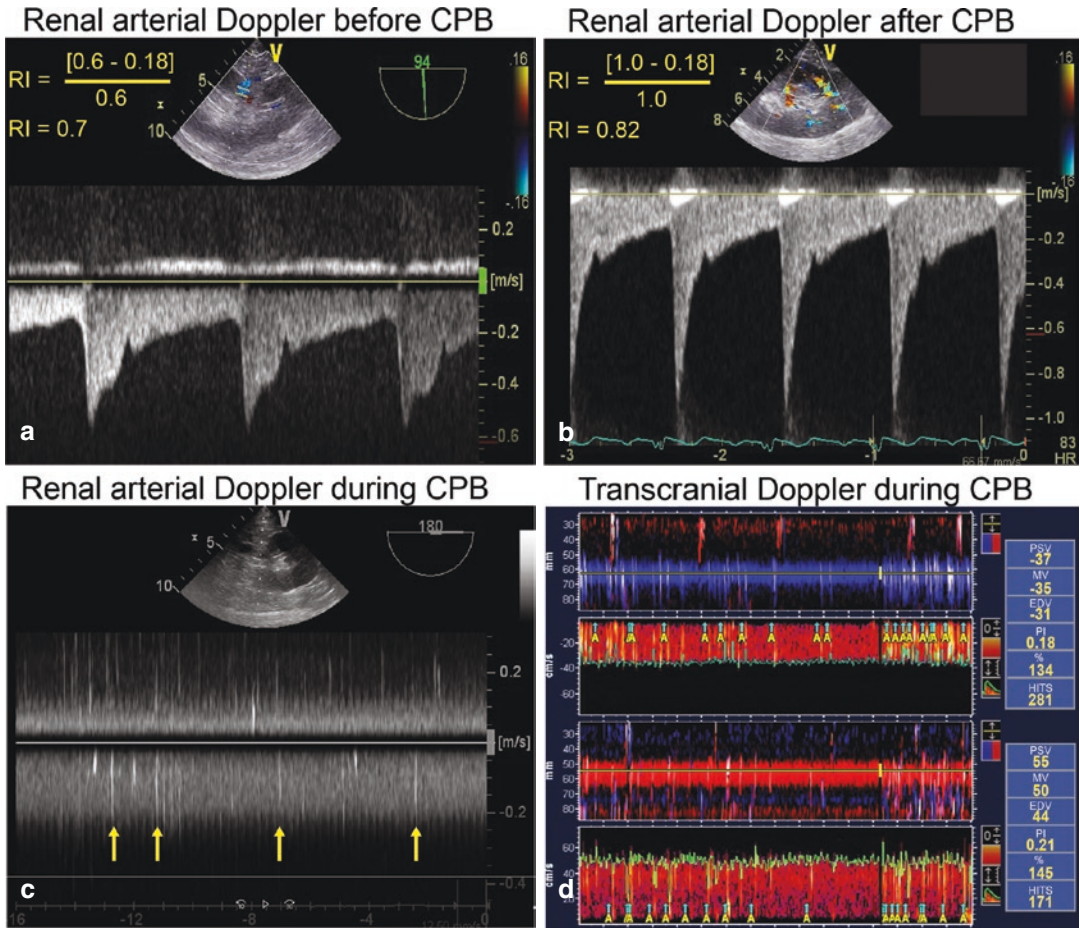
Arterial renal Doppler signal before (a) and after (b) cardiopulmonary bypass (CPB). Signals compatible with air embolism were seen on transesophageal echocardiography monitoring (c) and transcranial Doppler (d) during CPB. The renal resistive index increases from
